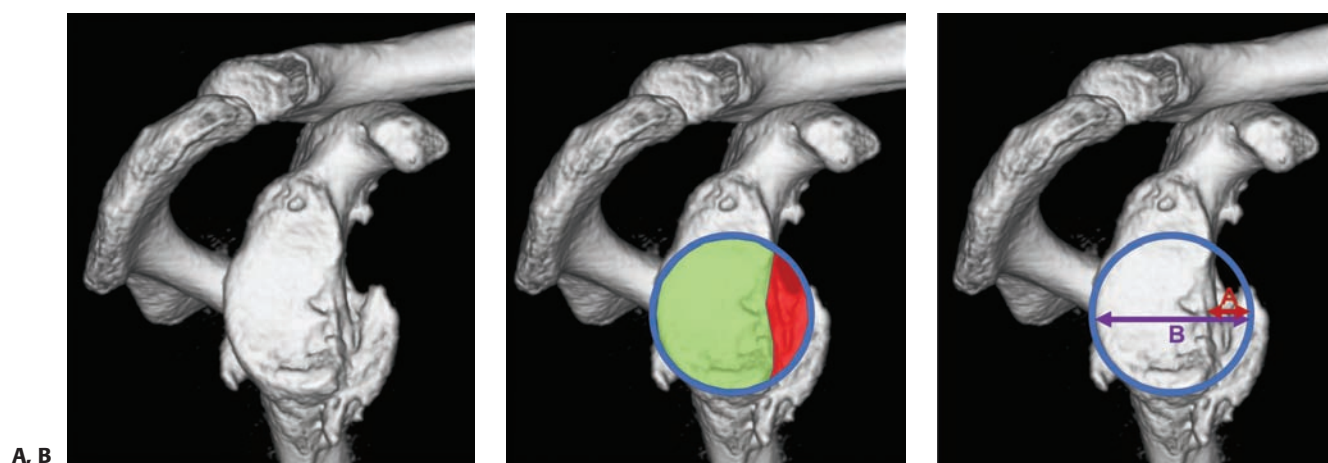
A: CT image with 3D reconstruction of the glenoid and en face view of the glenoid fossa. A large bony Bankart lesion is seen anteriorly with critical bone loss. B: Perfect circle is drawn to match the inferior 2/3 of the glenoid. Using the surface area method, the size of the glenoid defect is calculated by dividing the surface area of the bone defect (red) with the normal surface area of the entire glenoid fossa (circle). C: Another method of measuring glenoid bone loss is calculating the percentage defect of the glenoid based on a ratio of the missing anterior glenoid width (A) against the diameter of the assumed inferior circle of the entire glenoid (B). The percentage bone loss is $A/B \times 100 = \% \text{ bone loss}$.
